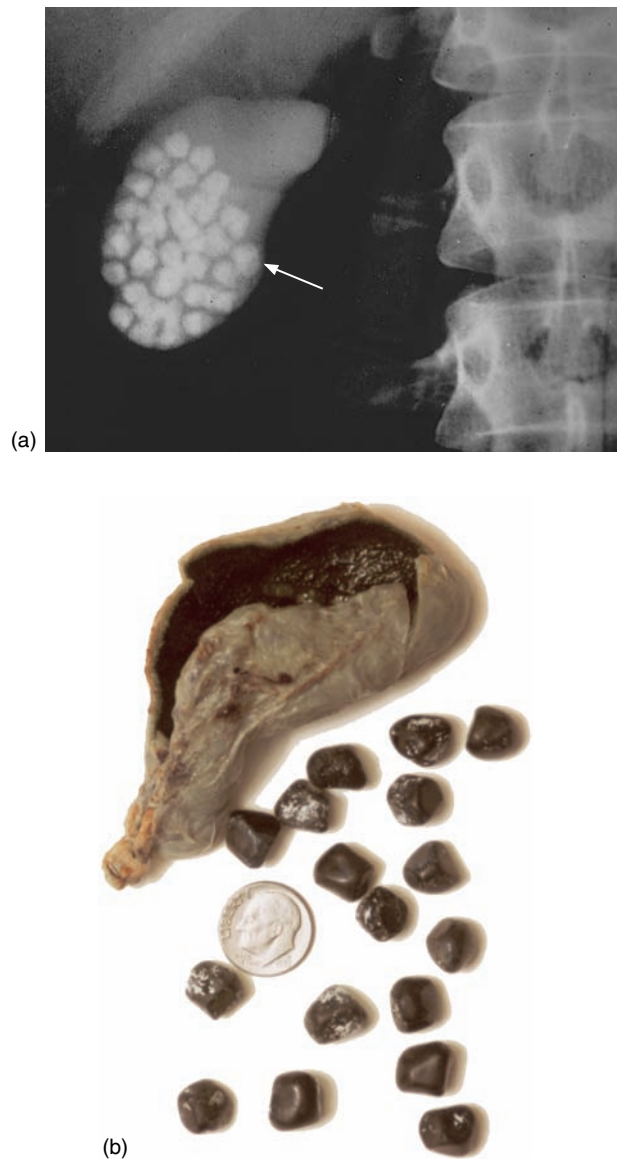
Gallstones. (a) A radiograph of a gallbladder that contains gallstones (biliary calculi). (b) A posterior view of a gallbladder that has been surgically removed (cholecystectomy) and cut open to reveal its gallstones. (Note their size relative to that of a dime.)
